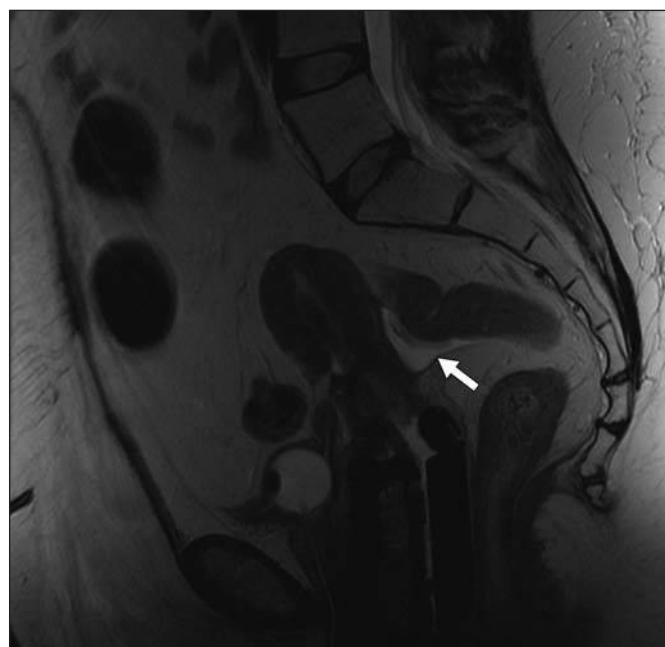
45-year-old woman with cervical cancer. Sagittal T2-weighted MR image of pelvis shows free fluid in pouch of Douglas (*arrow*).
